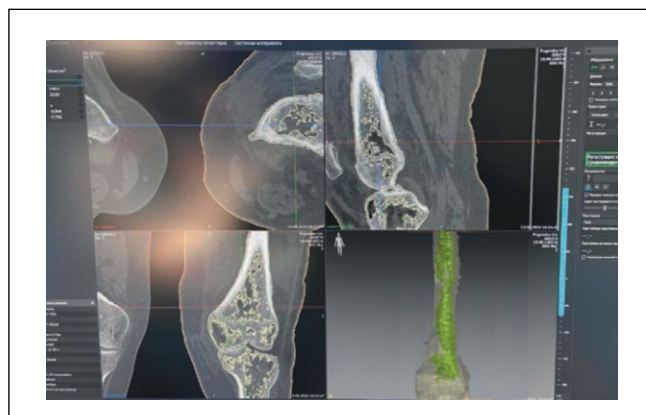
Computed tomography of the femur with the focus of osteomyelitis and the 3D model.
